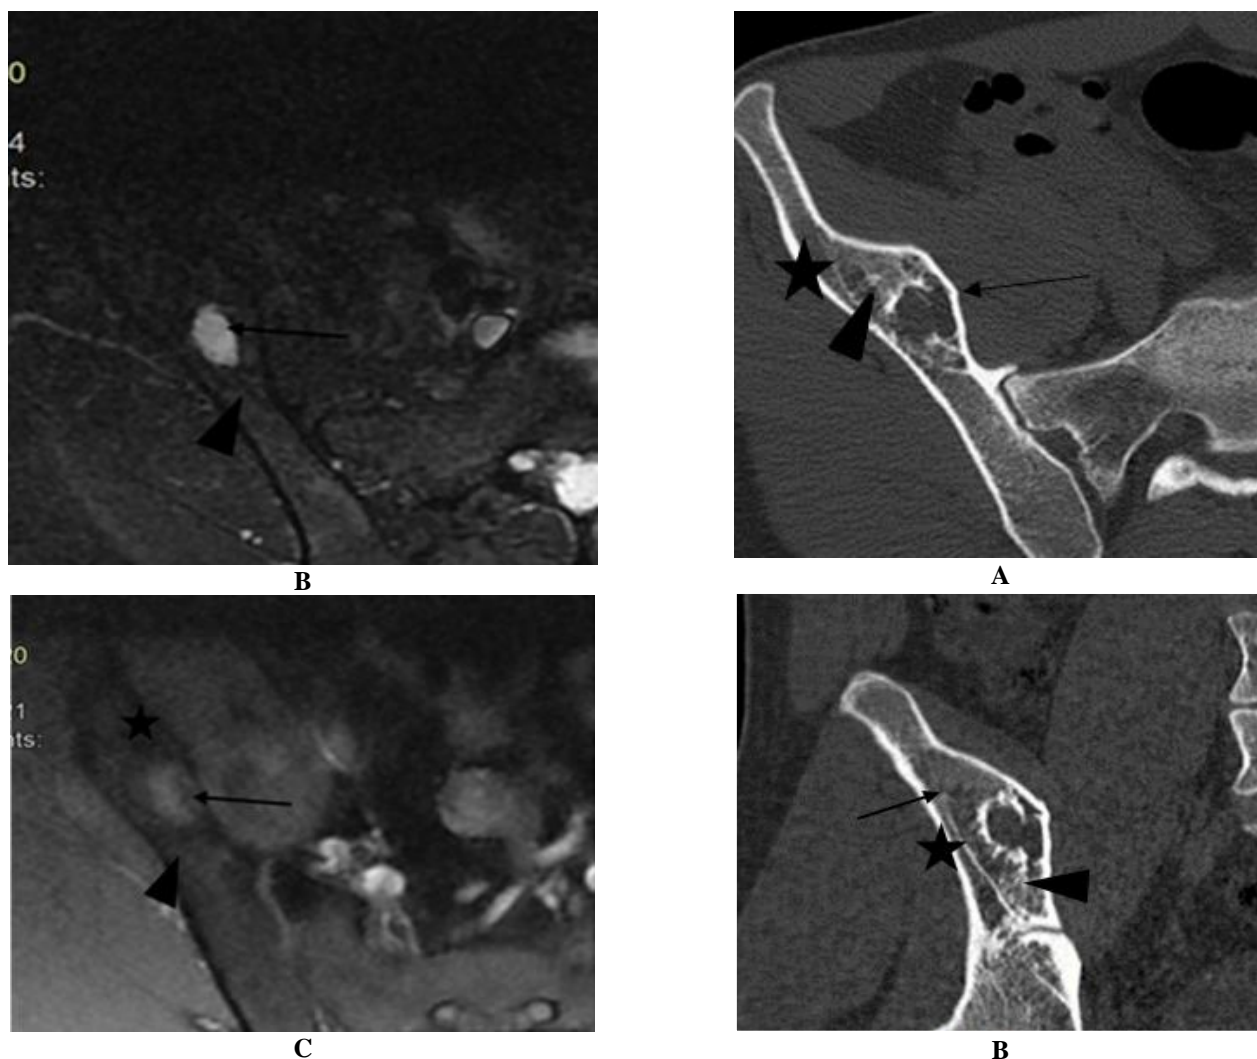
Axial T2-Weighted (A) MRI Image Shows A Bone Lesion Of The Right Iliac Wing, On Intermediate Signal Similar To The Bone Marrow Signal, Containing Trabeculae On Hyposignal (Stars) And A Central Area On Hypersignal (Arrows), Surrounded By A Fine Border In Hyposignal (Arrowheads). Axial STIR (B) And T1 FATSAT (C) Shows A Mucinous Cystic Central Area On Hypersignal (Arrows), Surrounded By A Fine Border In Hyposignal (Triangles).
